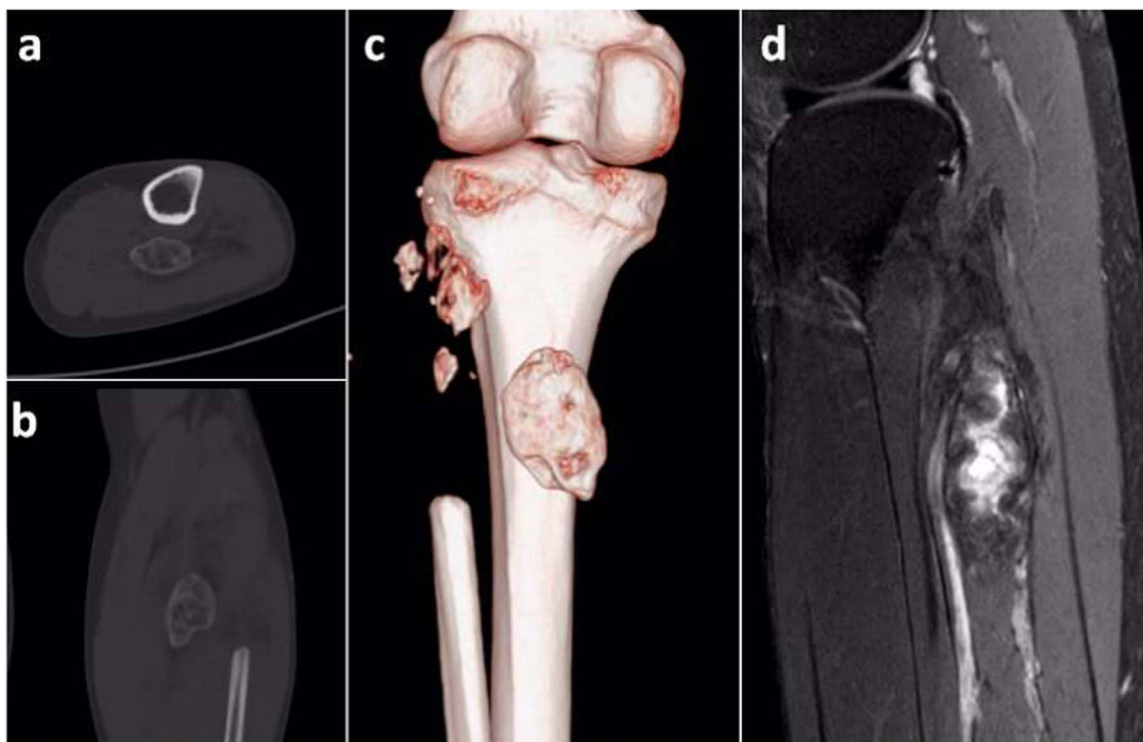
A 44-year-old female patient with giant cell tumor in the proximal left fibula. (a–c) CT scan of the left leg at the 17th month after surgery showed soft tissue nodular lesions with eggshell-like peripheral hyperdense rim. (d) On the cross-sectional fat-suppressed T2-weighted MR image, soft tissue masses revealed inhomogeneous high signal intensity.
